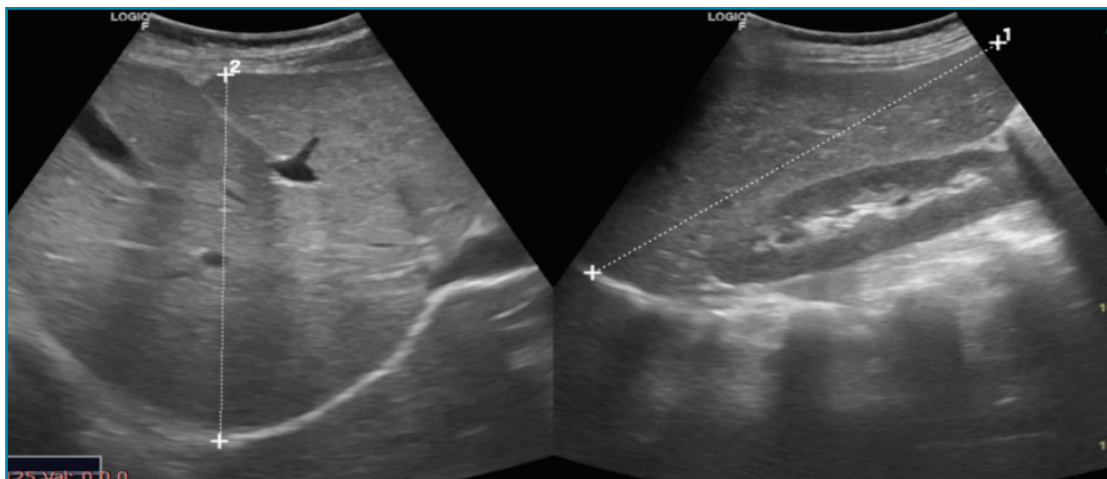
Sonographic measurements of liver and spleen.
